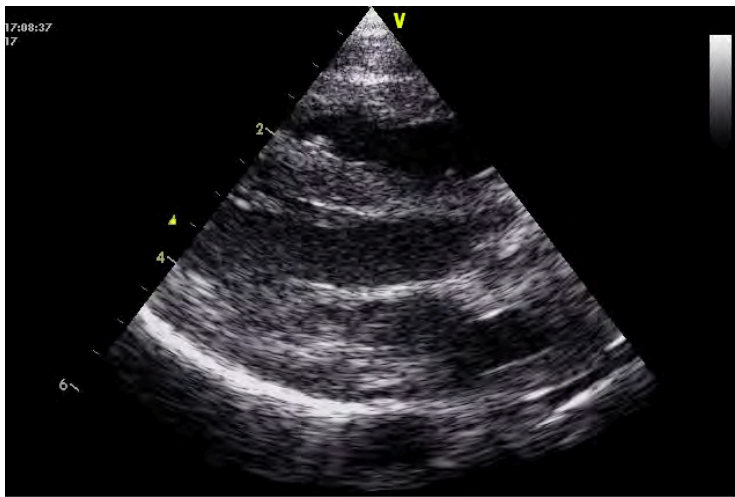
Echocardiography two days after conversion to sinus rhythm. Parasternal view showing a normal ventricle, left ventricle internal diameter of 19 mm.
